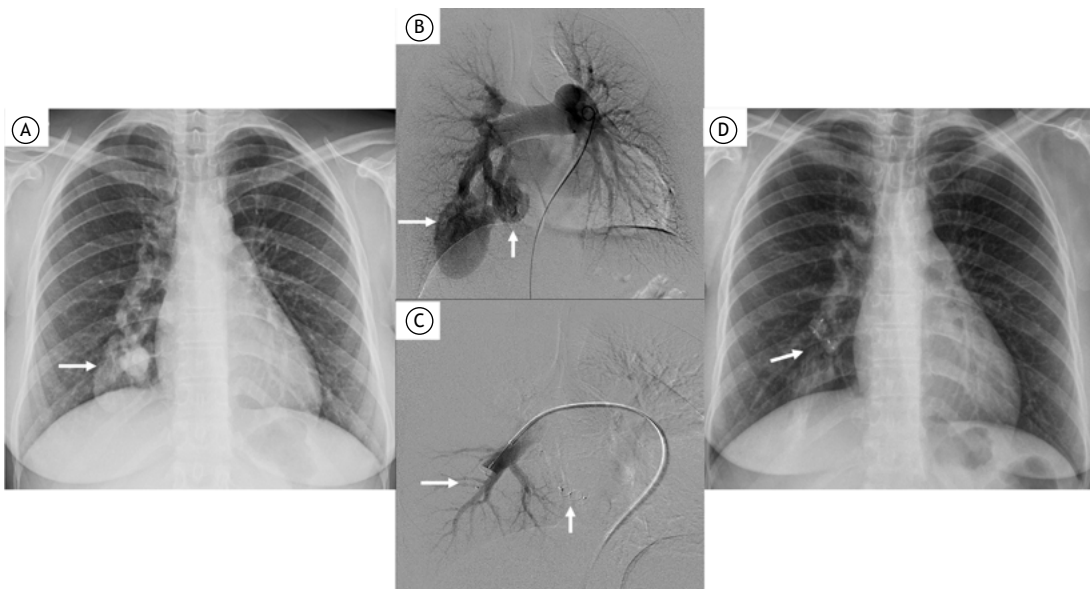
In A, a chest radiograph showing pulmonary arteriovenous malformations (white arrow) before embolization. In B, localization of the malformations by pulmonary angiography (white arrows). In C, embolization with Amplatzer vascular plugs (white arrows). In D, a chest radiograph after embolization (white arrow).
